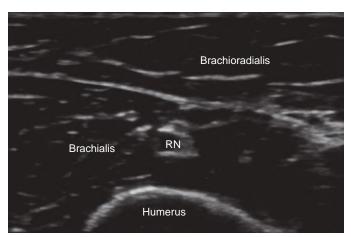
Ultrasound image of radial nerve (RN) at the level of the elbow.
